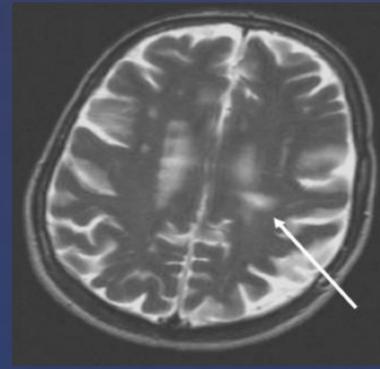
This T2 weighted MRI shows a bright area of demyelination within the normally dark appearing myelin.⁴
